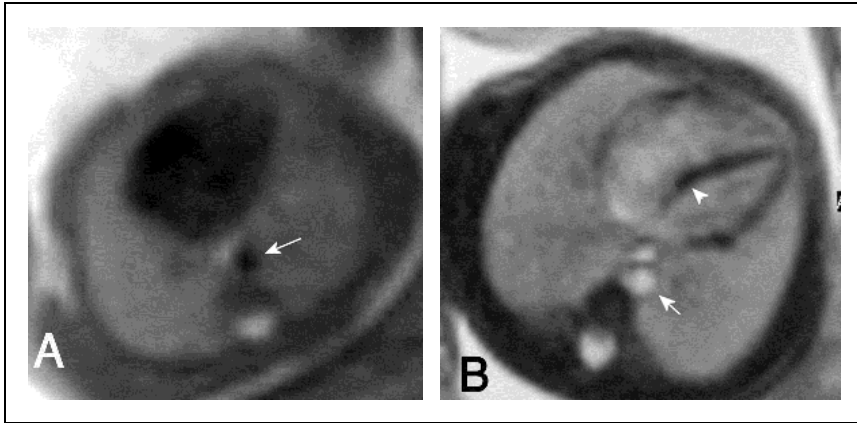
Axial MR images of fetal thorax at 24 weeks' gestation using dark blood sequence single shot fast spin echo (SSFSE) (A) and bright blood sequence steady state free precession (SSFP) (B). SSFP is superior in visualizing cardiac morphology, interventricular septum (arrowhead) and thoracic aorta (arrows).
